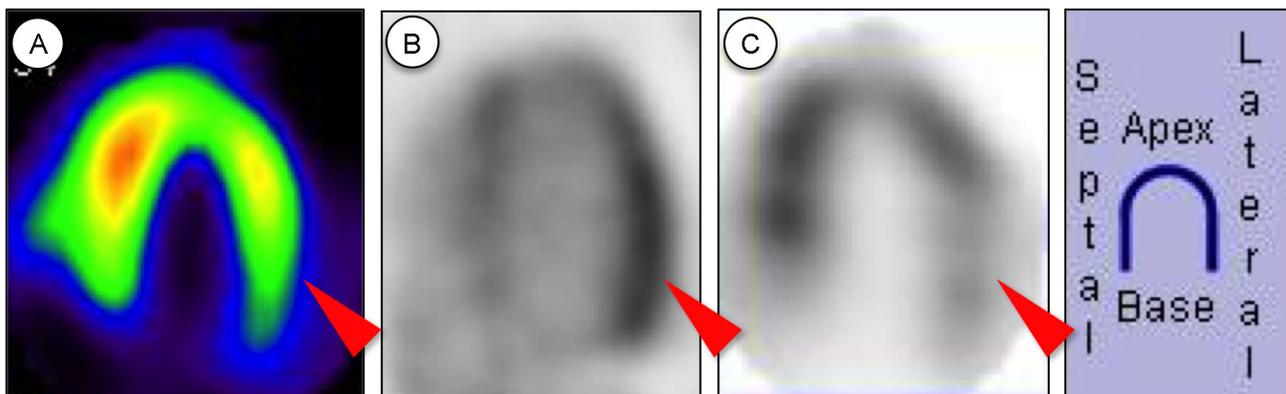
Technetium 99m sestamibi single-photon emission computed tomography (SPECT) (A), ^{18}F -fluorodeoxyglucose positron emission tomography (B) and iodine-123 beta-methyl-iodophenylpentadecanoic acid SPECT (C) on the 244th day, 239th day, and 241st day of admission, respectively.
